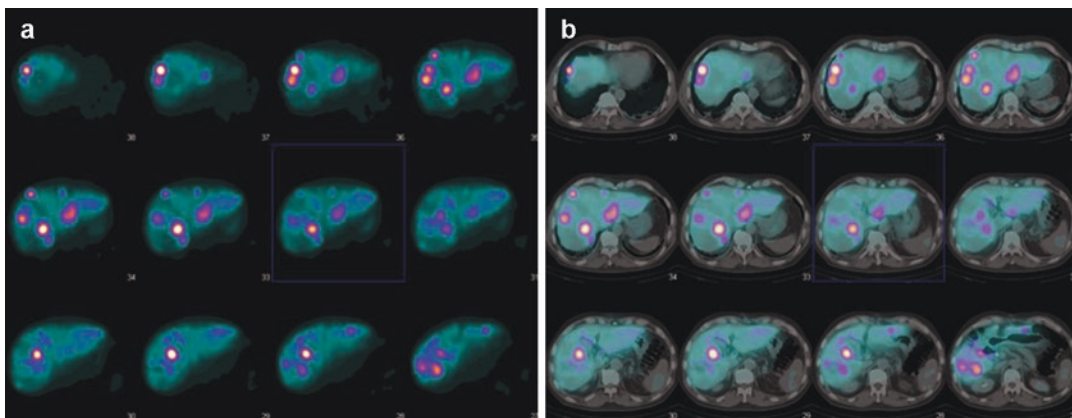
Comparison of $^{99\text{m}}\text{Tc}$ -MAA SPET imaging (a) versus $^{99\text{m}}\text{Tc}$ -MAA SPET/CT imaging (b) in multifocal liver metastases from colorectal cancer. SPET/CT localize
